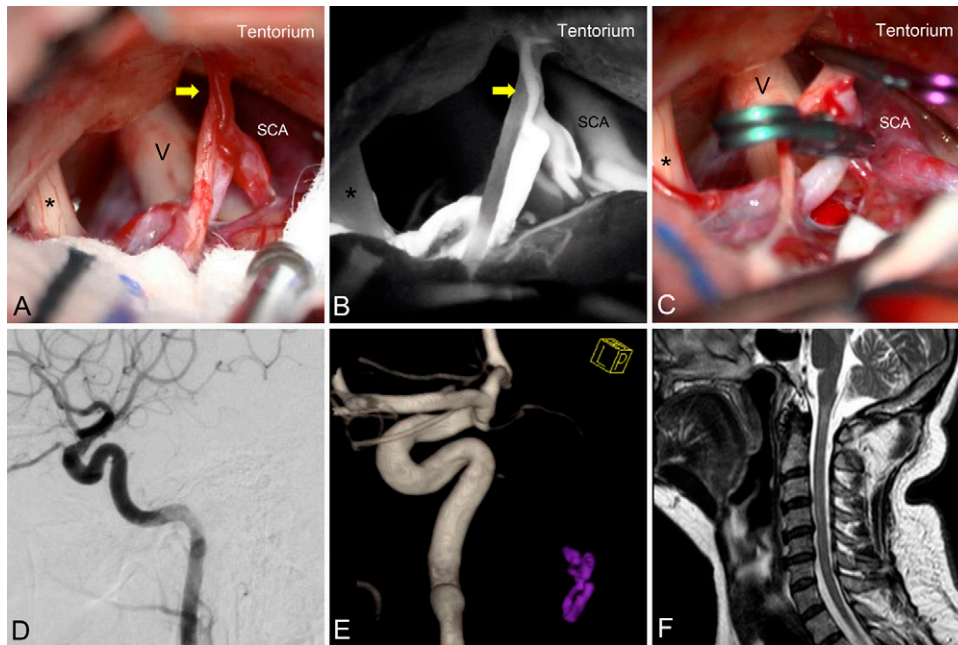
Intraoperative images (A–C) obtained after performing a left retromastoid craniectomy and durotomy below the transverse–sigmoid junction. Yellow arrows point to the arterialized vein hanging from the lateral inferior side of the tentorium. The trigeminal nerve (V), facial and vestibulocochlear nerves (*), and the superior cerebellar artery (SCA) are visible in the picture. Early indocyanine green video angiography (B) showed the DAVF tentorial arterial supply and its filling. Two straight aneurysm clips (C) were applied to disconnect the fistula. Postoperative left internal carotid arteriography (D and E) proving total DAVF closure. Postoperative MRI (F) showing a minimum residual amount of hyperintensity on a T2 sequence, with neither enlargement nor enhancement.
